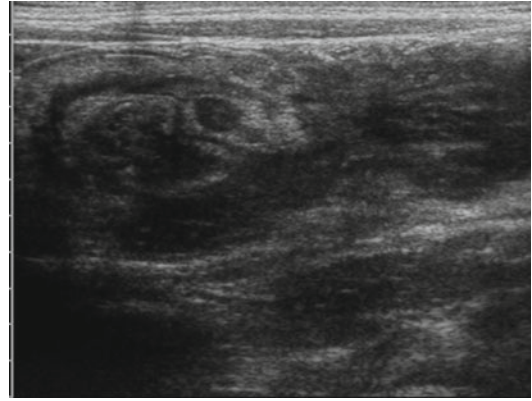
Ultrasound axial scan in an infant with intestinal intussusception shows an inhomogeneous rounded mass due to the herniation of the intussuscepted loop in the receiving one, with the mesenteric fat and lymph nodes in the center
